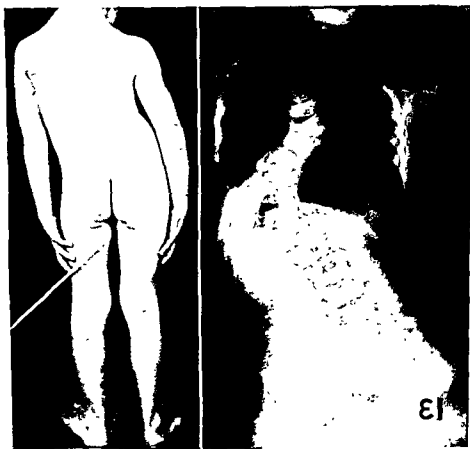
(Left) Clinical appearance. (Right) Preoperative roentgenogram
